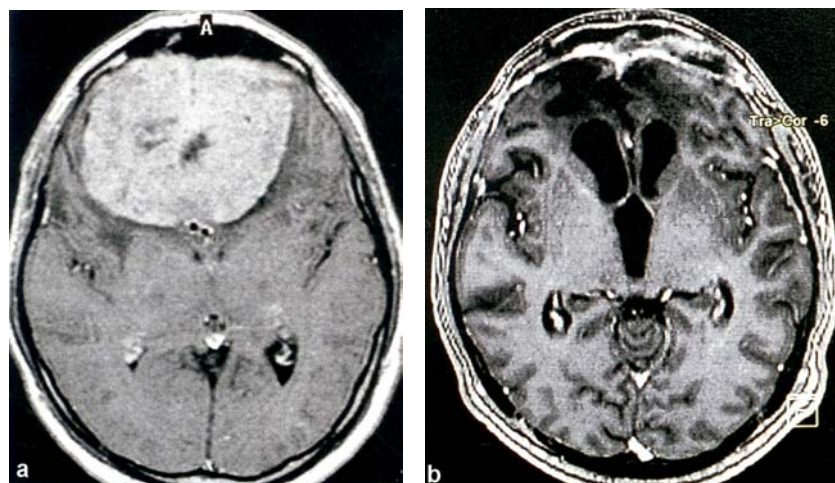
The preoperative contrast-enhanced computed tomography (CT) scan of a 29-year-old man which shows the presence of a giant size olfactory groove meningioma (a). The postoperative contrast-enhanced CT scan had shown no residual tumour (b). The patient had been admitted in the hospital because he had an important degradation of the sense of pudency associated with an orbitofrontal syndrome, which had disappeared after the surgical resection of the tumour (surgeon Leon Danaïla).
